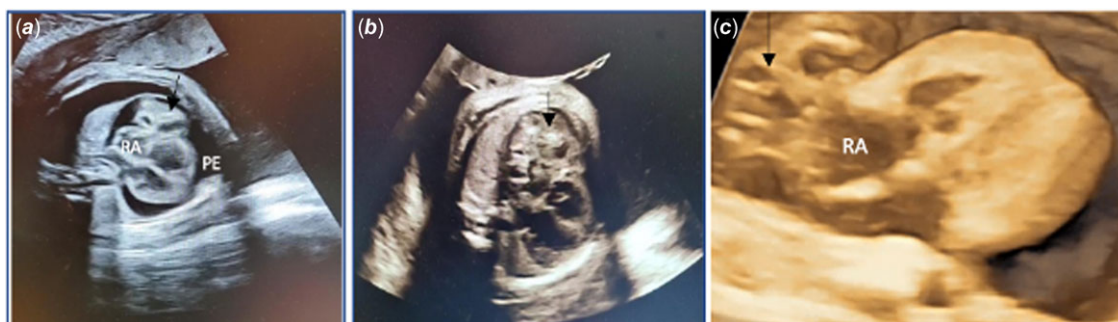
(a) Four-chamber view fetal echocardiography demonstrates an intrapericardial teratoma (black arrow), described as a 10 × 14 mm cystic mass near the right atrium (RA) with global pericardial effusion (PE). (b) A repeat fetal scan shows an increasing tumor size, (c) cystic heterogeneous mass from 3D scan view.
